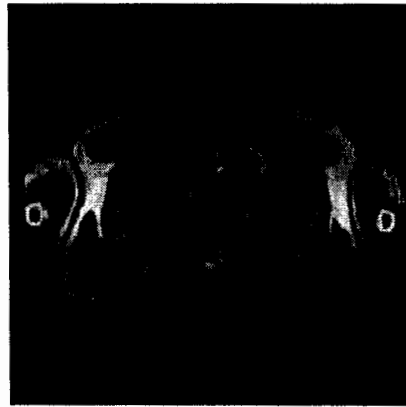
Fusion of CT and MR images of Chest by GEM
